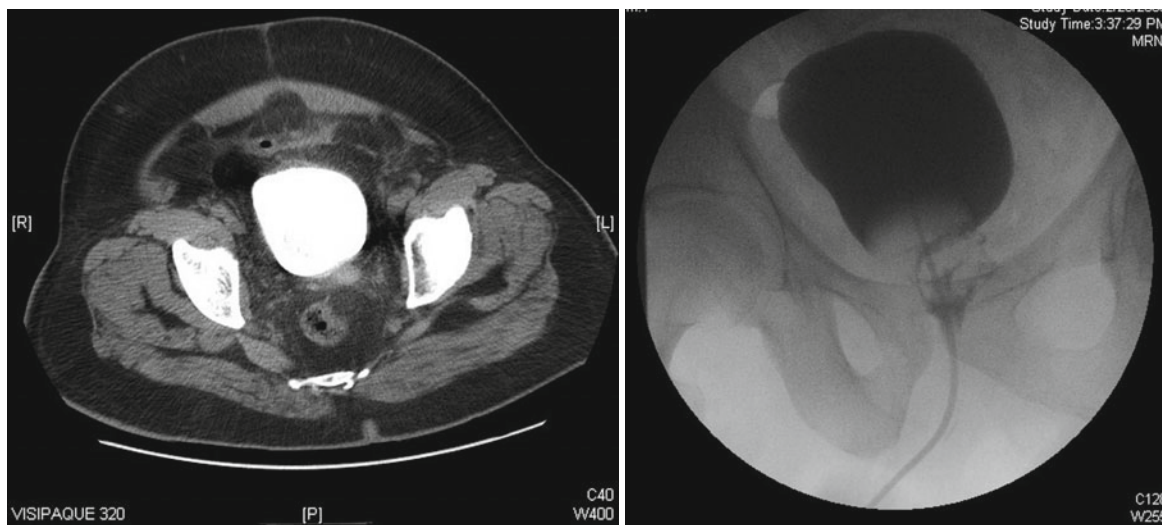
(a) Follow-up CT cystogram of the patient in Fig. 10, revealing no leakage. (b) Fluoroscopic image of a cystogram revealing no leakage
